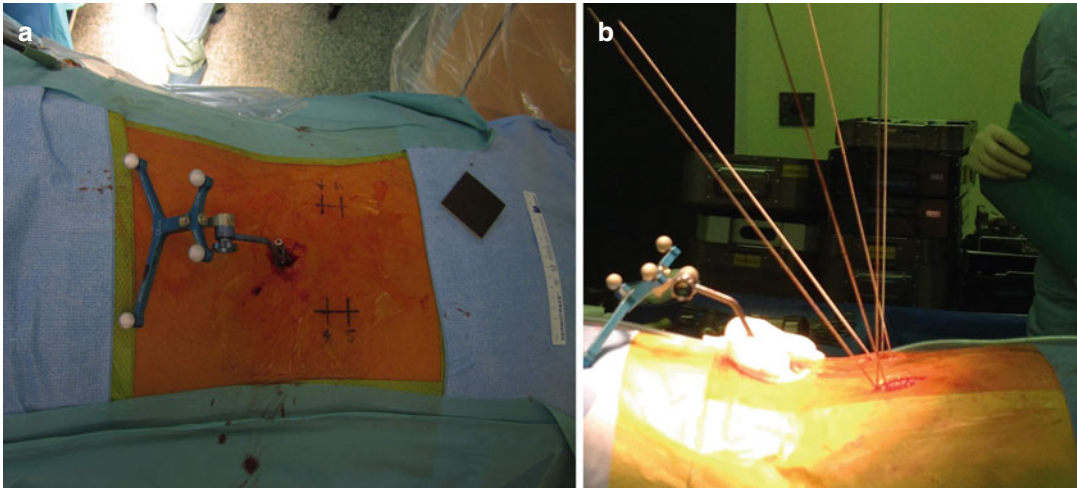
CT navigation system. The frame is fixed to the upper spinous process (a). Placement of the K-wires under navigation system without fluoroscopic control (b)
